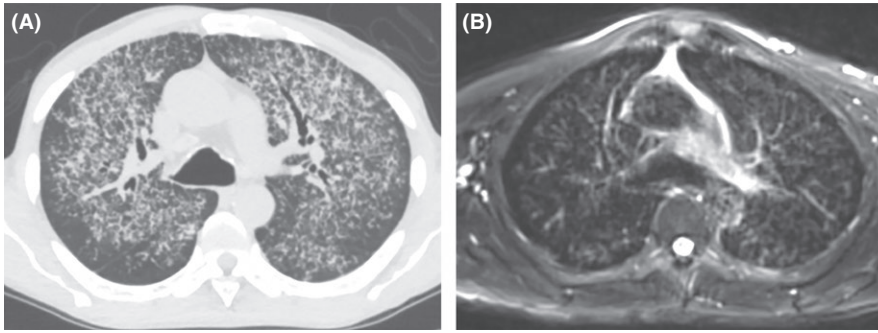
Images from a 67-year-old male with histoplasmosis and chronic cough. A, CT demonstrated diffuse centrilobular nodules in both lungs. T2 BLADE fat-saturated axial (B) and T1 VIBE coronal (C) sequences demonstrated the same findings. D, Axial diffusion-weighted sequence showing no restriction in the pulmonary nodules
